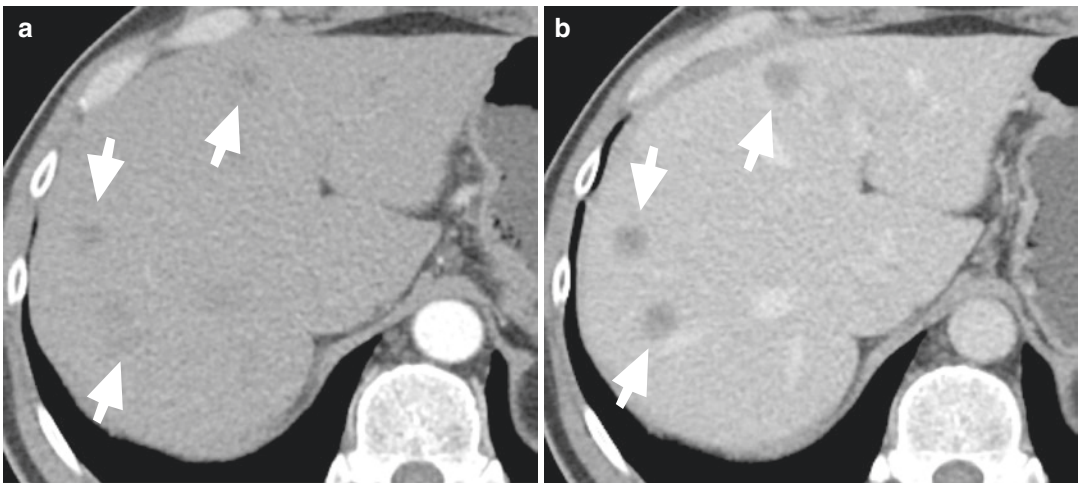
CT of CLMs in arterial (a) and portal-venous phase (b). Due to the hypovascularity of CLMs portal-venous phase provides the best imaging contrast for lesion detection (arrows)
